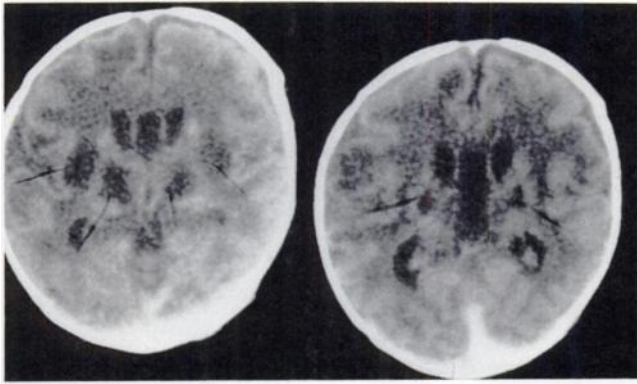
CT of Patient 12. Transaxial slices depict multiple areas of low density lesions consistent with hypoxic-ischemic encephalopathy.
